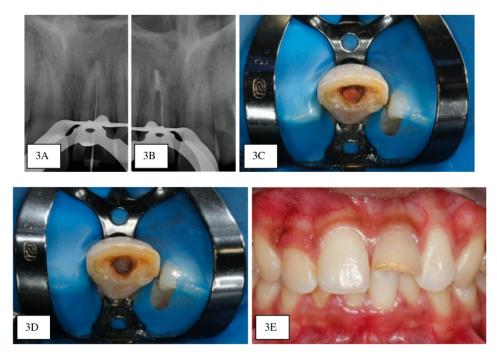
Treatment sequences of tooth #21 in case 1. A. Working length confirmation using radiograph. B. Radiograph confirmation of mineral trioxide aggregate placemented. C. Obturation of the root canal. D. Wing barrier using glass ionomer cement before intracoronal bleaching. E. After intracoronal bleaching.
